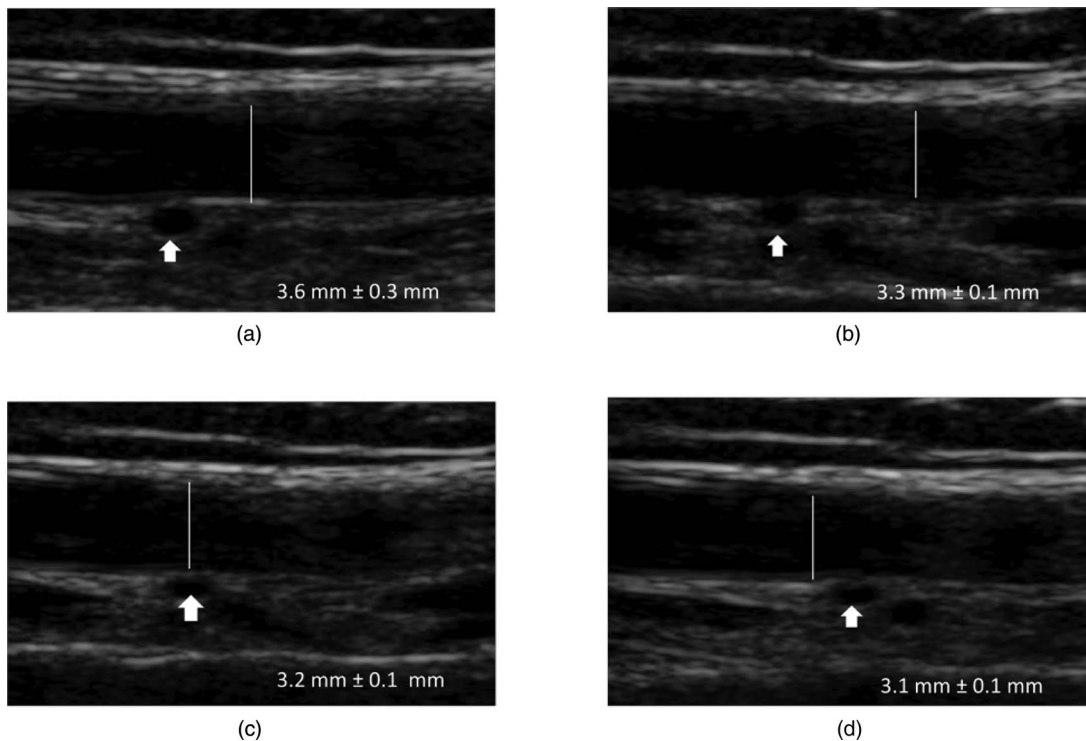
Ultrasound transducer pressure compression of the brachial artery. Increasing the subjective external transducer pressure from (a) low, to (b) modest, to (c) moderate, to (d) high, decreases the manually measured artery diameter and collapses a small vessel (arrow).
